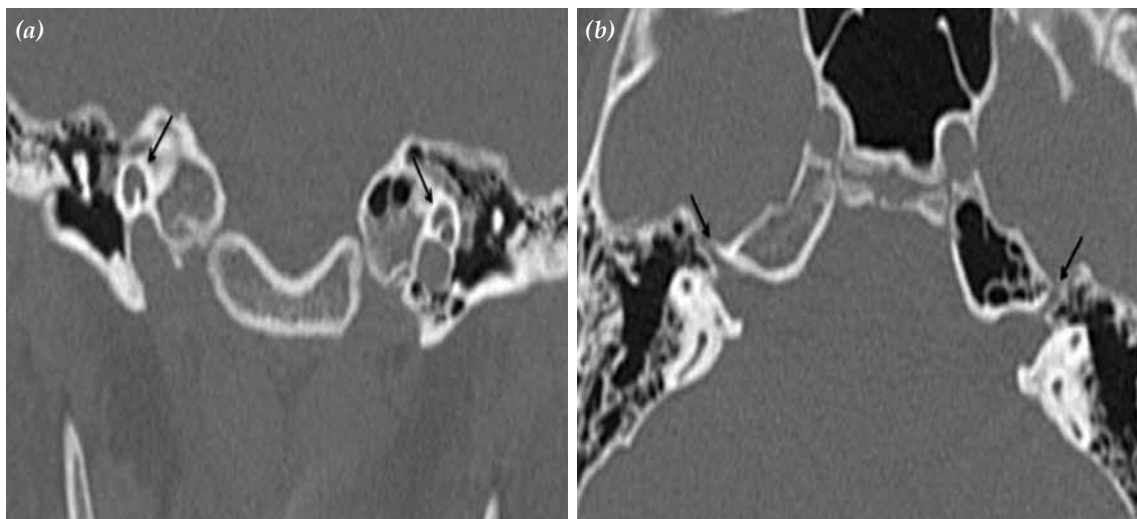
High resolution computed tomography, coronal section (a), showing bilateral cochlear hypoplasia (arrows); Axial section (b), showing bilateral enlargement of the labyrinthine segments of the facial nerve canals (arrows).
